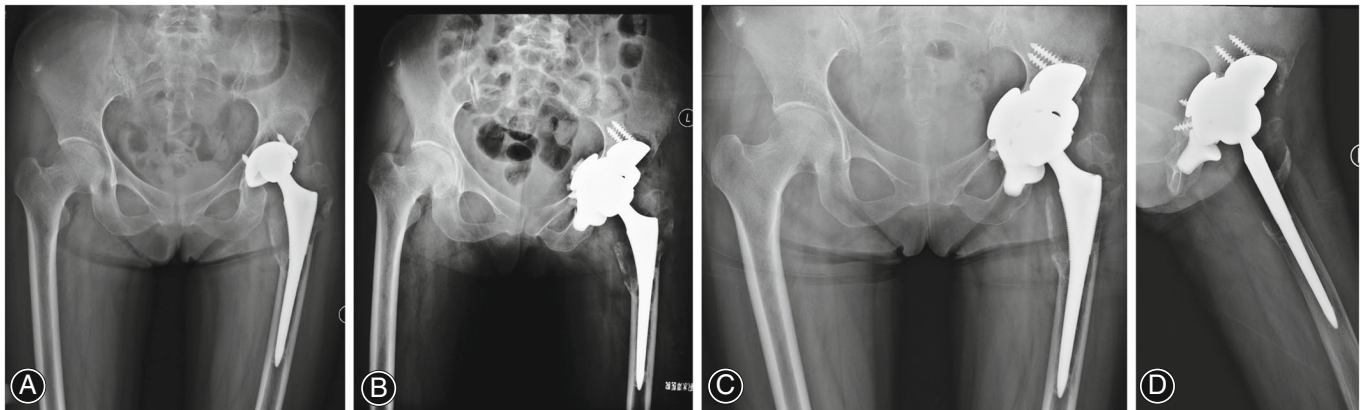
A representative case of extended ischiopubic fixation using a lotus augment. (A) Preoperative anteroposterior radiograph of the bilateral hips of a 49-year-old female demonstrating loosening of the left cup and substantial left ischial osteolysis. (B) Immediate postoperative anteroposterior radiograph of the bilateral hip demonstrating a lotus augment impacted into the ischium to reconstruct an ischial supportive point and a TM slope augment secured in the ilium to simultaneously reconstruct a firm superior supportive point (note the TM restrictor augment medial to the cup to reconstruct bone defect in the medial wall). Postoperative anteroposterior (C) radiograph of the bilateral hips and the lateral view (D) of the left hip with 2.2-year follow-up demonstrating a stable construct on the left side with no radiolucent lines around the cup and augments
